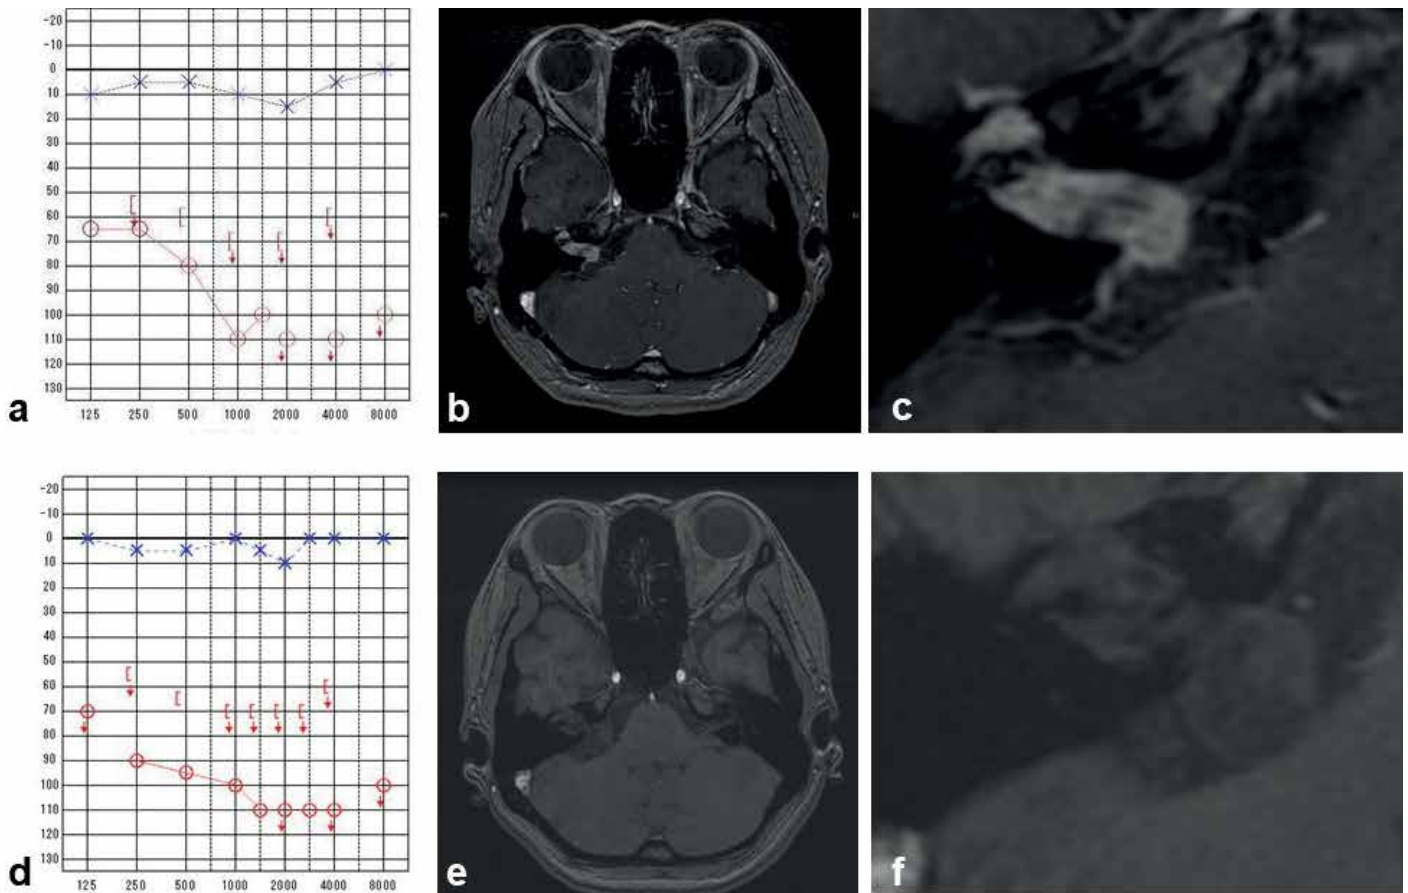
a-f. Preoperative course of audiogram and MRI imaging. Preoperative course of audiogram and MRI during the 5-year preoperative observation period, during which the patient completely lost her hearing (a, d). Tumor protruding into the cerebellopontine angle. The mass grew to 22 mm and extended from the cerebellopontine angle to the geniculate ganglion (b, c, e, f).
